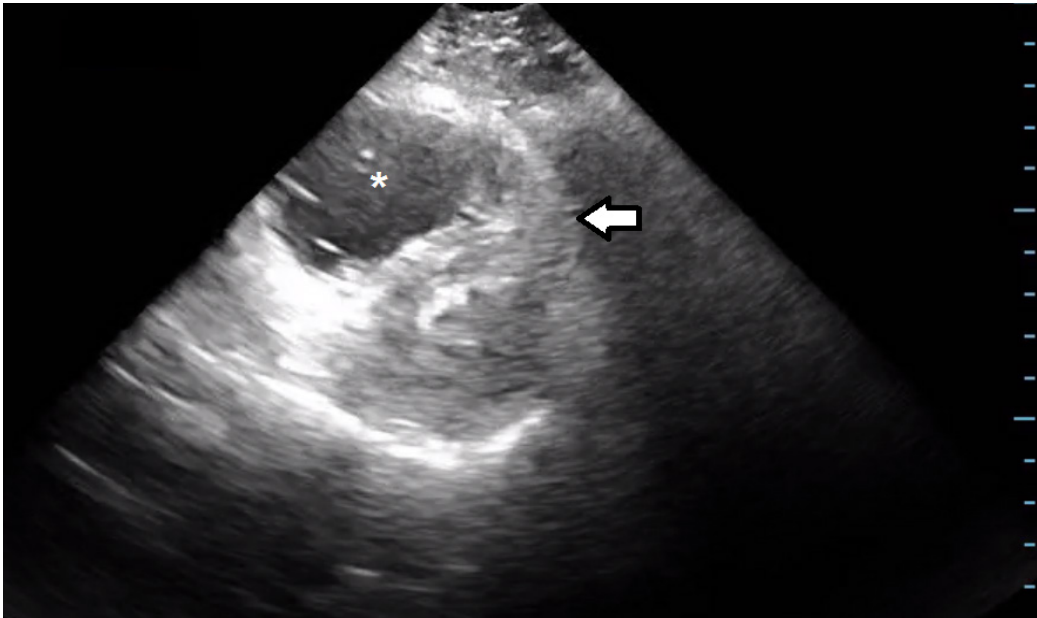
Point-of-care cardiac ultrasound, short-axis view demonstrating right ventricular dilation (asterisk) and paradoxical septal position (arrow).
